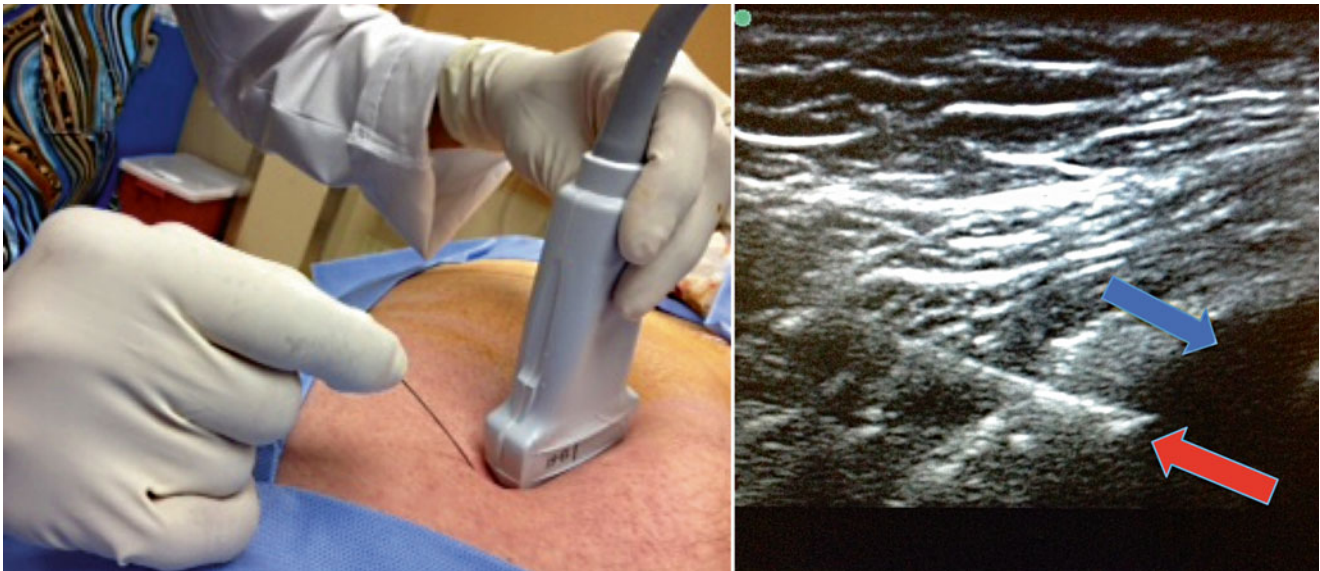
Ultrasound image of the inferior cluneal nerve. *Blue arrow* = ischium; *red arrow* = needle injection (Image courtesy of Terri Dallas-Prunskis, MD)
